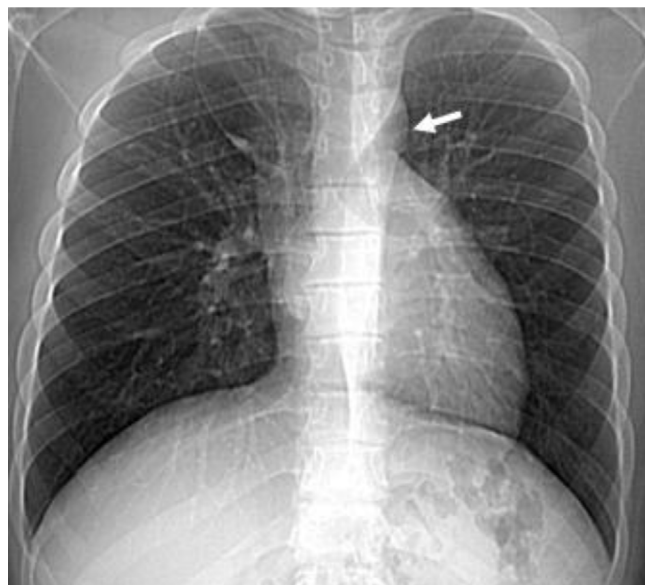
CT scout view was showing a lucent area between the aorta and pulmonary artery (white arrow).
